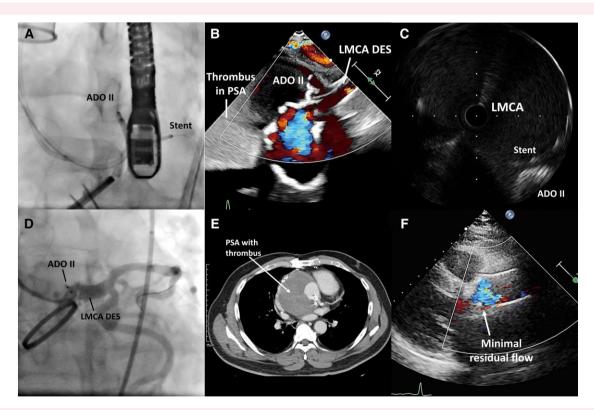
Peri-operative and post-procedural images. (A) Fluoroscopy showed the Amplatzer Duct Occluder II 6 × 4 mm was deploying at the inlet of pseudoaneurysm, and a drug-eluting stent was standing by in the left anterior descending coronary artery. (B) Transoesophageal echocardiography with colour Doppler confirmed well-seated occluder with immediate thrombus formation and patent blood flow of the left main coronary artery. (C) IVUS after post-dilatation showed the optimization of stent expansion of the left main coronary stent, and the position of the occluder was secured by the coronary stent. (D) Final angiogram showed coronary button dehiscence was secured by the occluder and left main coronary stent, and coronary blood flow was TIMI-III flow. (E) Post-procedural chest computed tomography revealed thrombosis of aortic root pseudoaneurysm. (F) Post-procedural transthoracic echocardiography revealed minimal residual leakage in parasternal long-axis view with colour Doppler. ADO II, Amplatzer duct occluder type two; DES, drug eluting stent; IVUS, intravascular ultrasound; LMCA, left main coronary artery; PSA, pseudoaneurysm; TIMI, thrombolysis in myocardial infarction.
